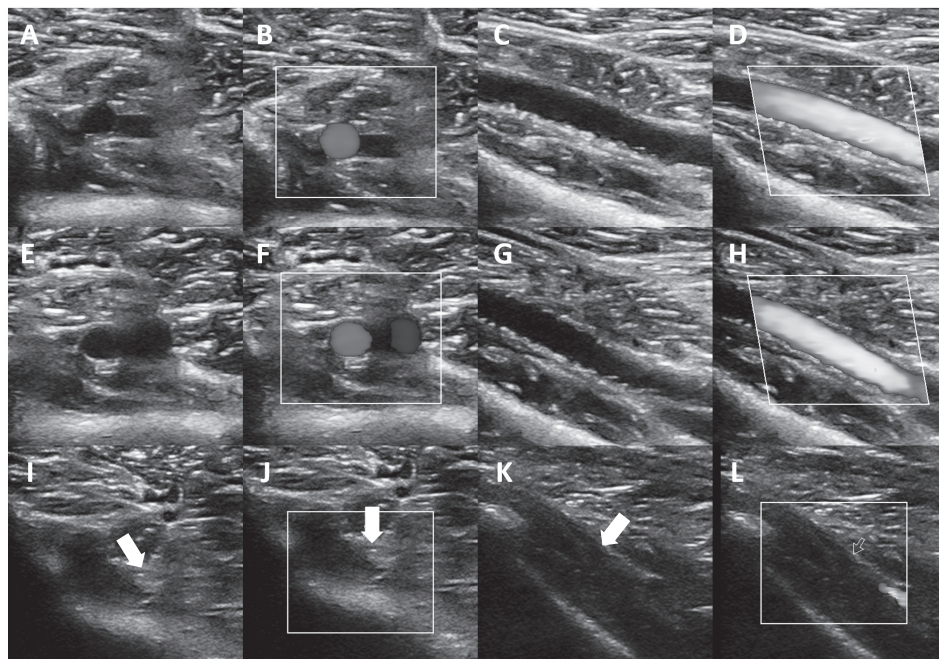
B-mode and colour Doppler ultrasound images taken of the distal popliteal artery in an asymptomatic elite athlete in transverse (TS) and longitudinal sections (LS) in the prone position. (A–B) TS image taken at rest; vessel widely patent. (C–D) LS image taken at rest; vessel widely patent. (E–F) TS image taken in forced dorsi-flexion; vessel widely patent. (G–H) LS image taken in forced dorsi-flexion; vessel widely patent. (I–J) TS image taken in forced plantar flexion; complete vessel compression noted. (K–L) LS image taken in forced plantar flexion; complete vessel compression noted. White arrows indicate location of complete artery compression.
